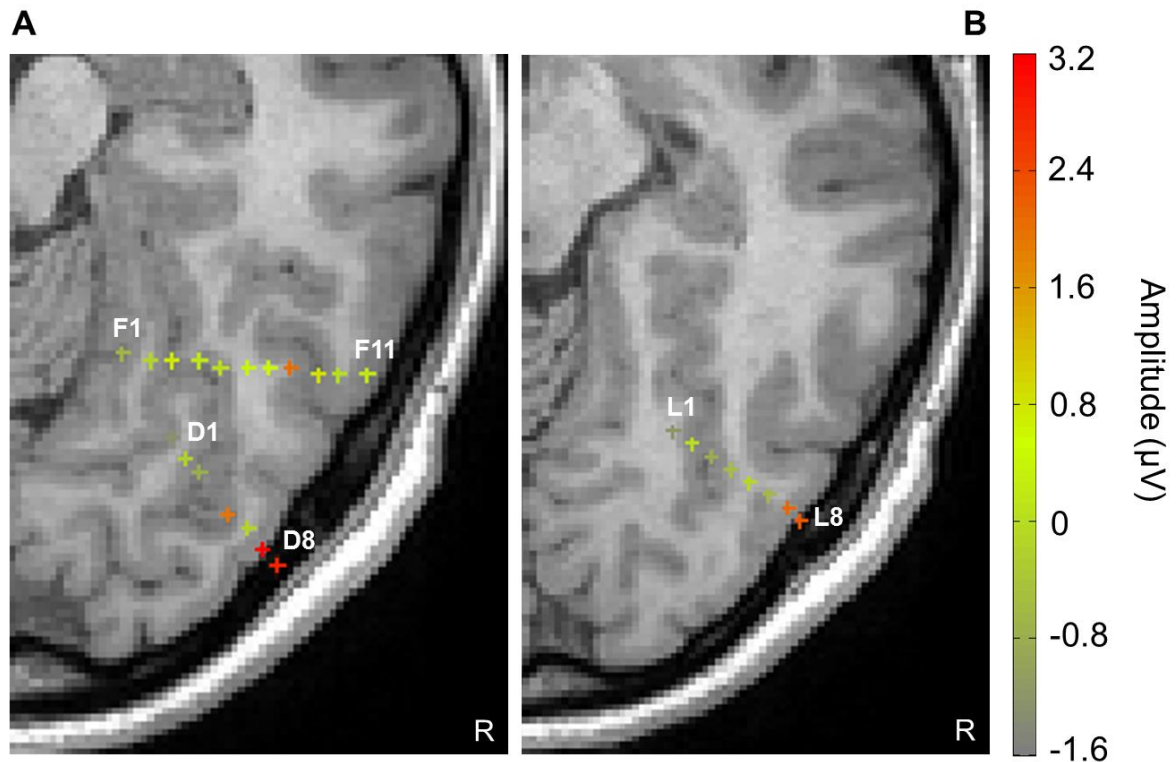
Anatomical location of individual face repetition suppression effects for the upright condition on MRI axial slices. A. Electrodes D and F. B. Electrode L. Each contact is represented by a cross. The color of the cross indicates the magnitude of repetition suppression in the upright condition. Only the most medial and the most lateral contacts of each electrode are named. Electrode L is located slightly above electrodes F and D. Note that the largest repetition suppression is located in the lateral section of the right inferior occipital cortex. Contact D8 is the most lateral contact of electrode D and was not located inside the brain but sitting on the surface of the lateral occipital cortex.
